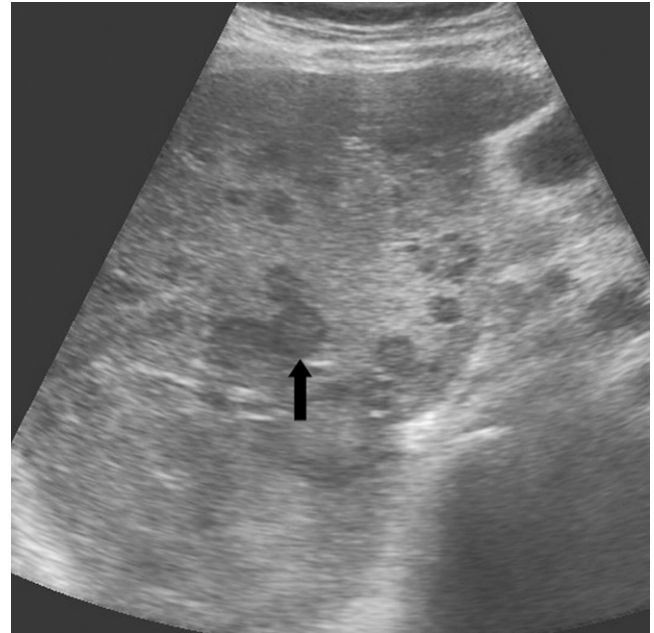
Ultrasound showing multiple liver metastasis with a target-like appearance (black arrow) in a patient with a known primary colonic cancer.
